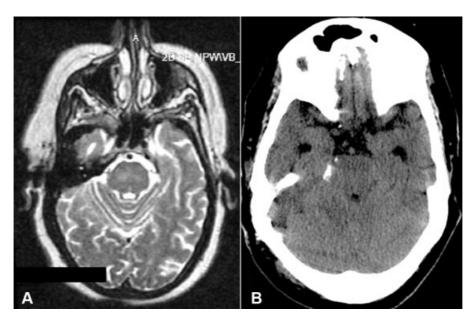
(A) Preoperative T2-weighted axial magnetic resonance imaging (MRI); (B) Postoperative noncontrast axial computed tomography (CT) of brain.
